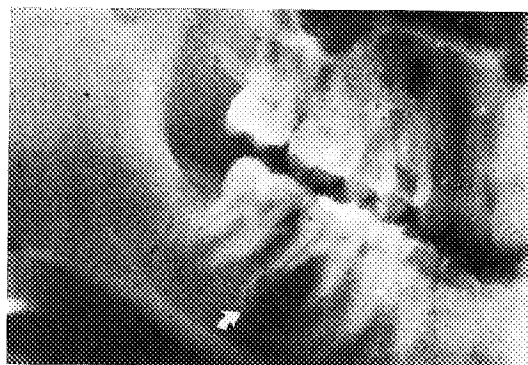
Cementoma. Axial CT scan shows a heavily calcified periapical mass (arrow). (Courtesy of M. Mafee, MD.)
